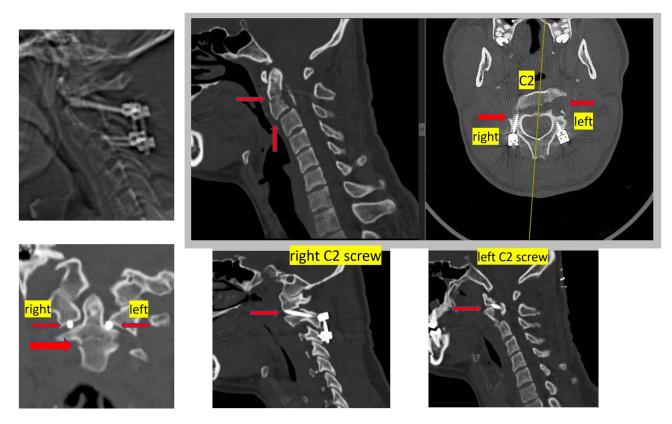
Figure I CT images revealing status post the initial surgery performed at another centre. Red arrows point to key abnormalities seen on the CT scans that underlay our decision to perform revision surgery: C2-C3 displacement/instability, fracture of the C2 vertebral body with detachment and anterior displacement of a part of the C2 body, fracture of the C2 pars interarticularis on the right, and incorrect location of screws within C2, with their ends seen within C1-C2 joint spaces, making it impossible for the patient to perform rotational head movements.
